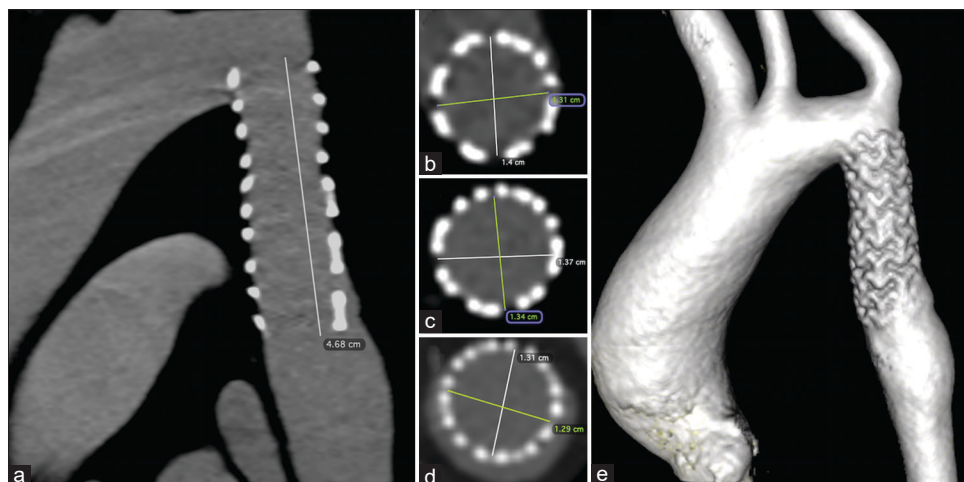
Multiplanar reformatted view shows the stent in the long axis view of the aortic arch (a) on computed tomography at 6-month follow-up. The cross-sectional views at the upper, (b) middle (c), and lower (d) levels and volume rendered image (e) show good opposition of covered stent to the aortic wall without any evidence of pseudoaneurysm. The stent length is 46.8 mm demonstrating negligible foreshortening
